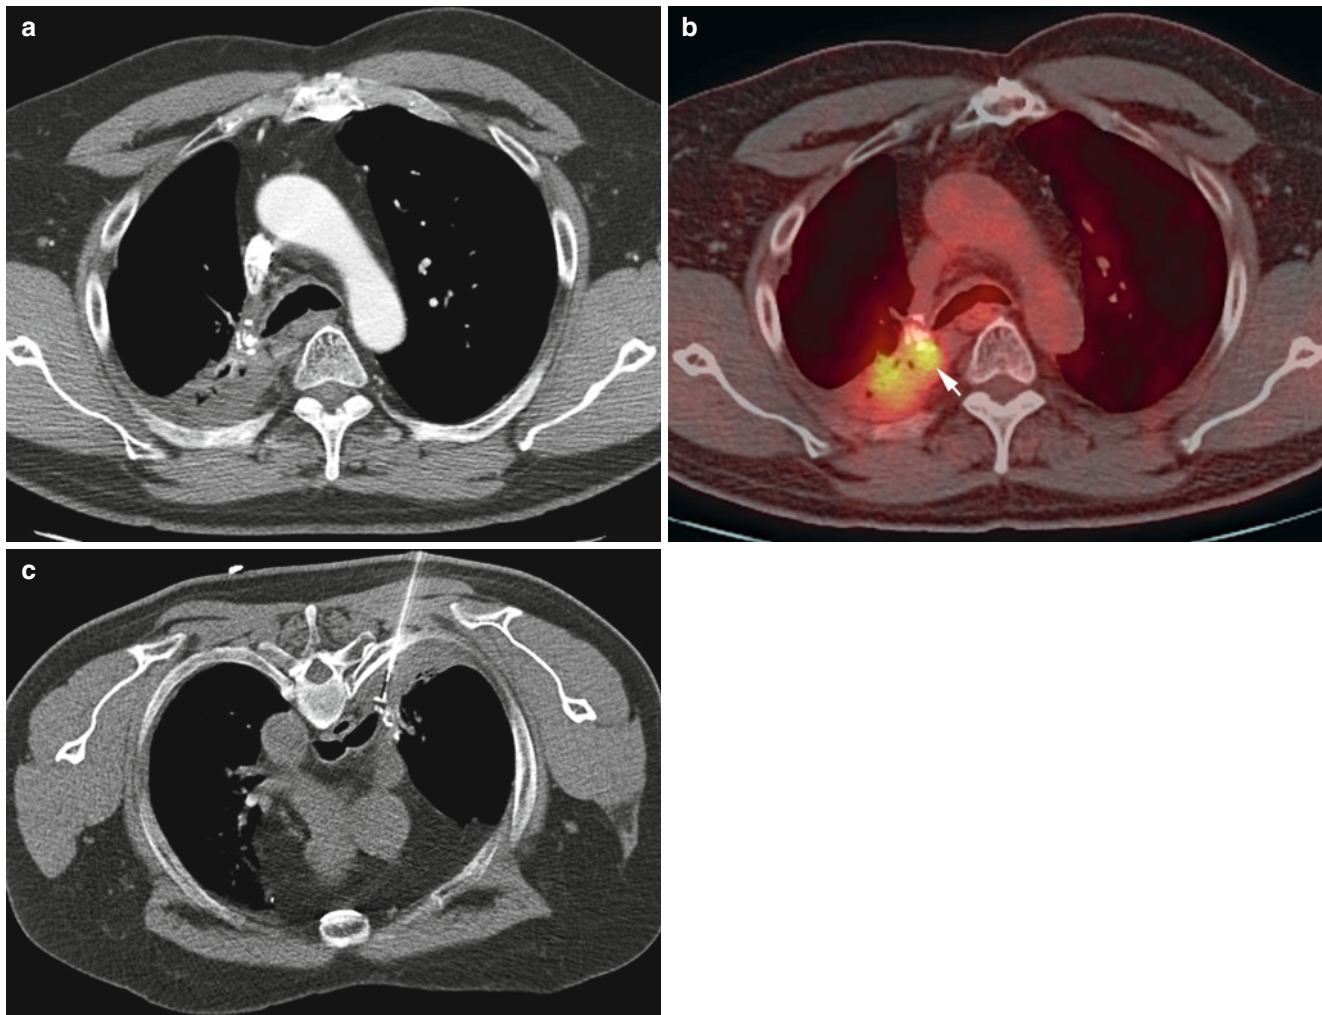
A 72-year-old man with history of non-small cell lung cancer and right upper lobectomy underwent surveillance CT imaging. Axial CT image of the chest (a) shows a new soft tissue mass in the posterior aspect of the right chest. PET/CT image of the same area
